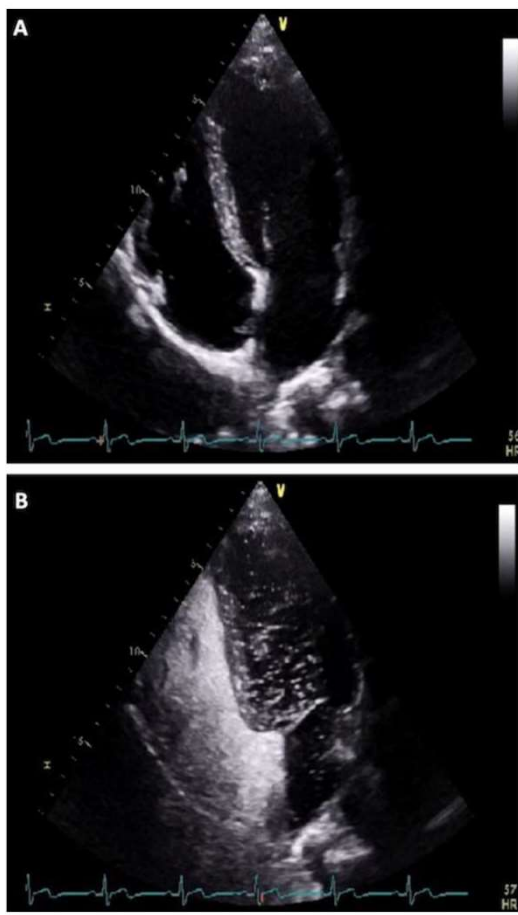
Patent foramen ovale (PFO) detected on transthoracic echocardiography: (A) transthoracic echocardiography detecting large PFO without saline contrast use; (B) transthoracic echocardiography with Valsalva induced rise in the right atrial pressure and increase saline contrast passage through the PFO. Note that the Valsalva technique causes the cardiac chambers to become smaller (confirming that the Valsalva has been effective) and then concentrates the bubbles in the right atrium.
